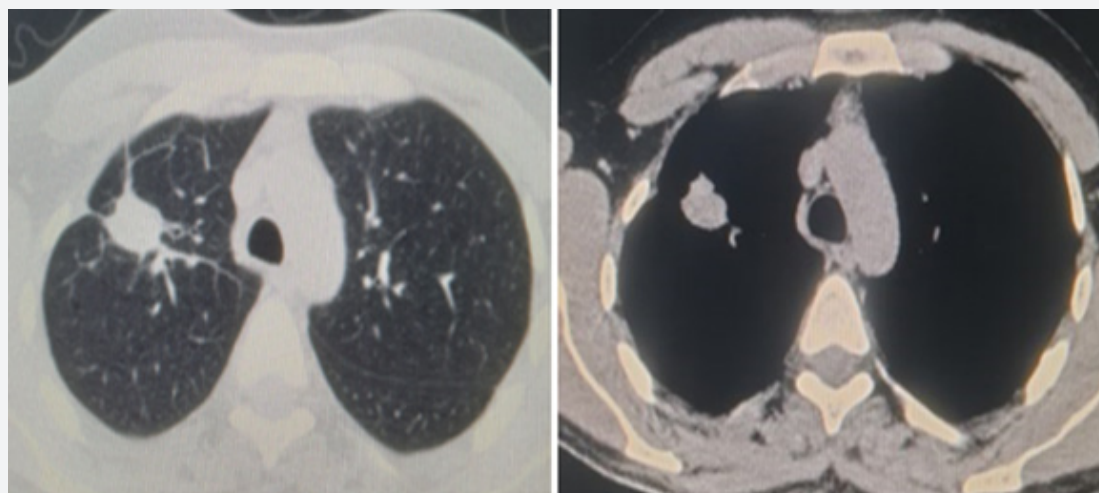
A repeat CT thorax in axial lung and mediastinal windows after six months of trauma showing a residual homogeneous mass with hypodense contents replacing the cavity in right upper lobe.
